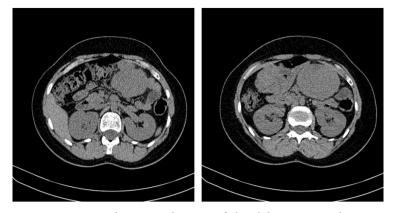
Computed tomography scan of the abdomen in axial section showing the ileal tumor process.
